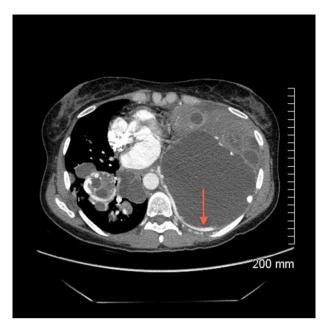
Computed tomography image showing the largest cyst 13×11.5 cm. Red arrow pointing at the 1–2 mm pulmonary arteriovenous malformation before the cyst was drained.
